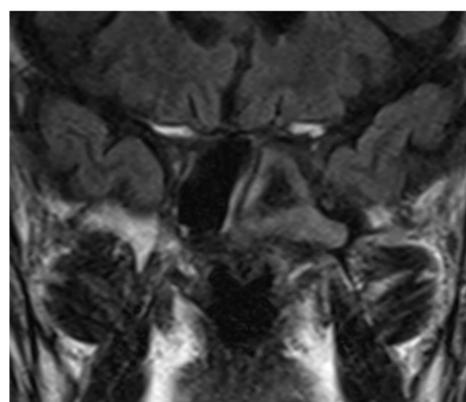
MRI of the sphenoid sinus with central hypointensity typical of a fungal ball
